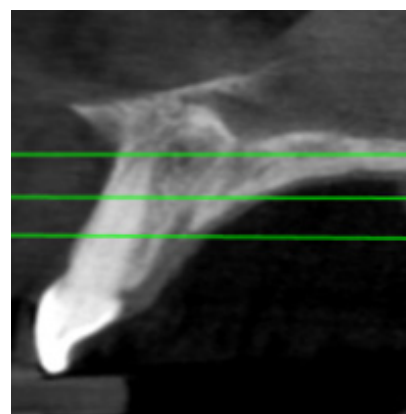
Vertical levels in CBCT
